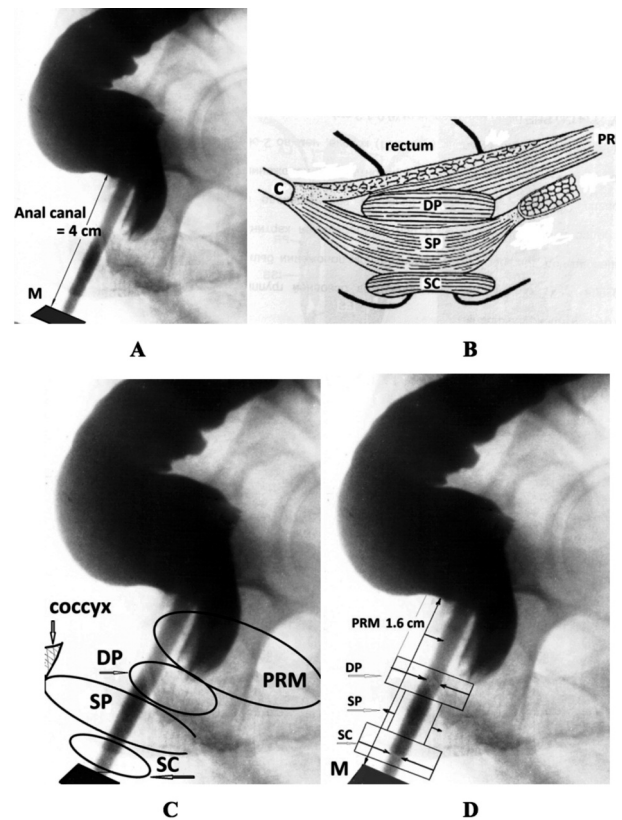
The combining of the manometric study, anatomical data and X-ray imaging of the anorectal area (lateral view).
